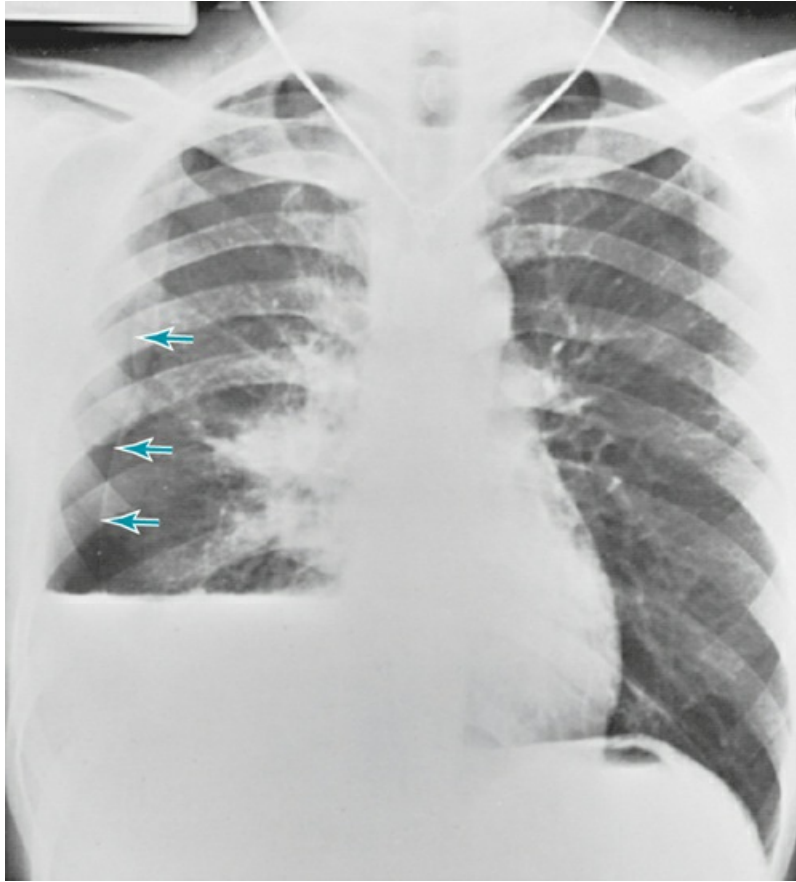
Chest radiograph shows right hydropneumothorax. Horizontal line in lower right hemithorax is interface between air and liquid in pleural space. *Arrows* point to visceral pleura above level of effusion. There is air in pleural space between visceral pleura and chest wall.
